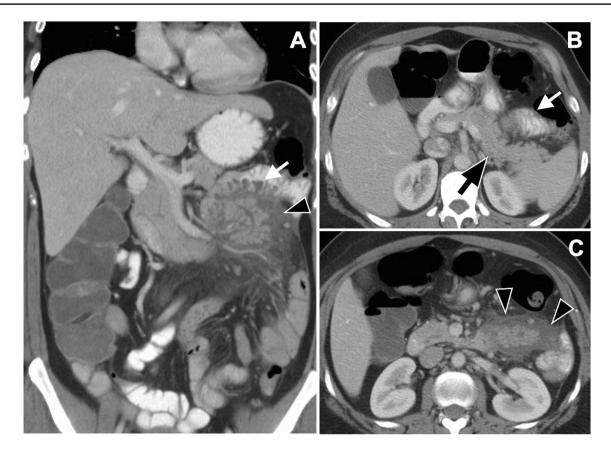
Contrast-enhanced CT was performed in a patient with unclear abdominal pain and elevated lipase. a: Coronal reformation shows an ectopic pancreas in the right middle quadrant with peripancreatic free fluid and fat stranding (arrow head). The adjacent fluid-filled jejunum
